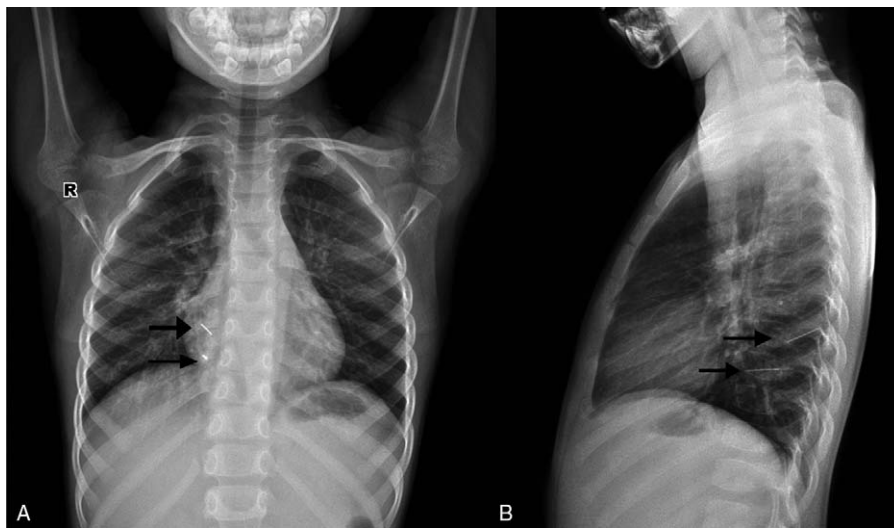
Chest X-ray images in coronal and sagittal views: case 1. Black arrows indicate the segments of the needle.
